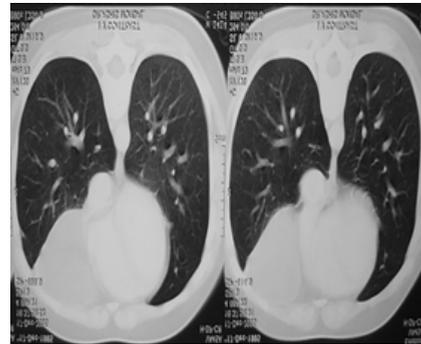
CT Scan showing anterior mediastinal mass
